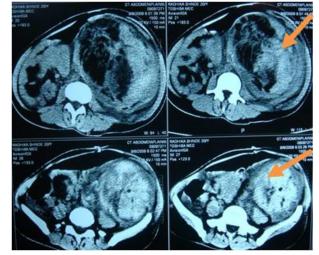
CT abdomen showing renal mass
